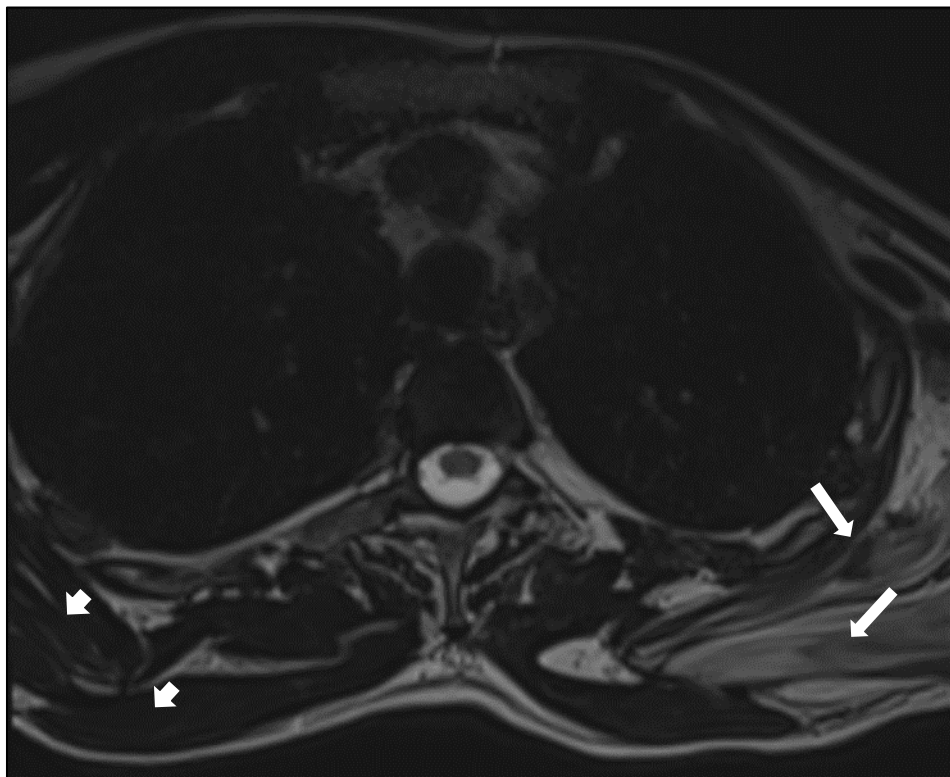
Axial T2-weighted image at the cervicothoracic level demonstrating asymmetric atrophy and signal heterogeneity of the left infraspinatus (IS), supraspinatus (SS), and subscapularis (Sub) musculature (white arrows), compared to the preserved muscle bulk on the contralateral right side (arrowheads). These findings reflect chronic denervation of muscles innervated by the posterior rami and proximal branches of the affected nerve roots, providing an indirect MRI sign of preganglionic injury.
